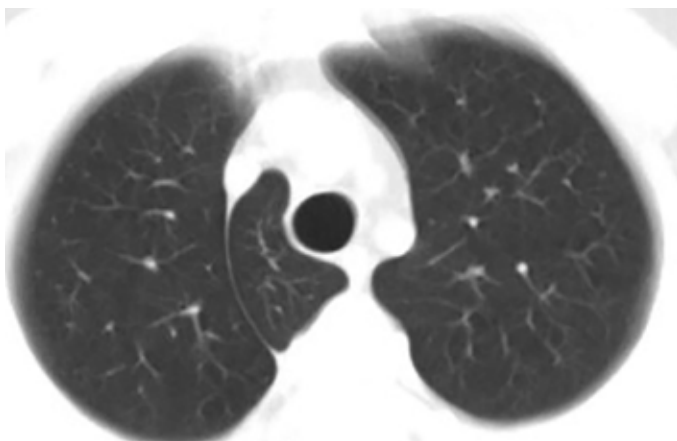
Computed tomography axial image in different variations
